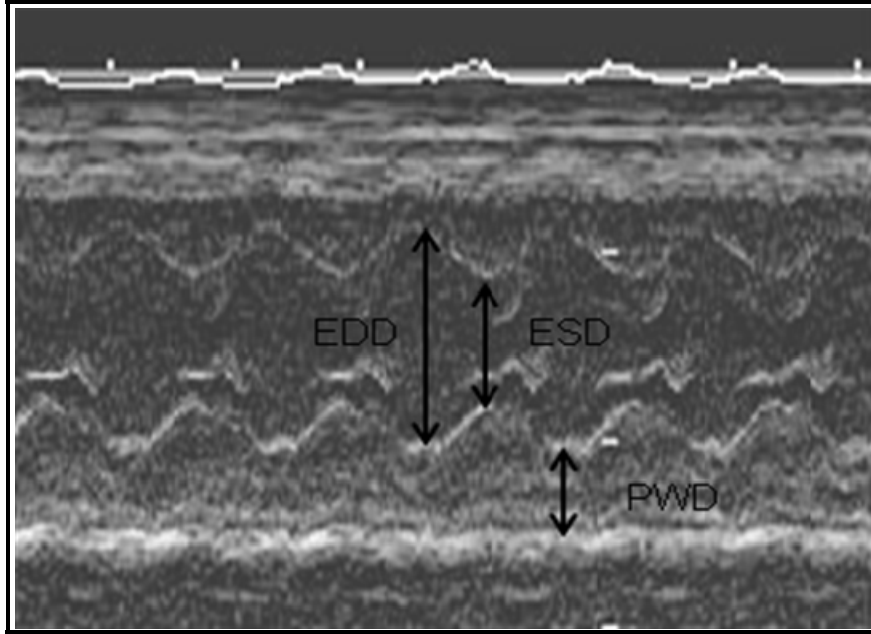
In-vivo myocardial function measurements by 2D transthoracic echocardiography
